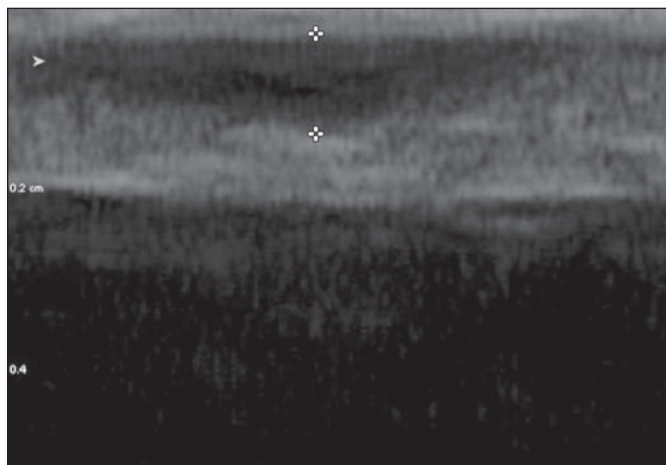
68-year-old man with cutaneous melanoma of lumbar region. Ultrasound image shows ultrasound thickness is 1.09 mm. Breslow index is 1.1 mm.
